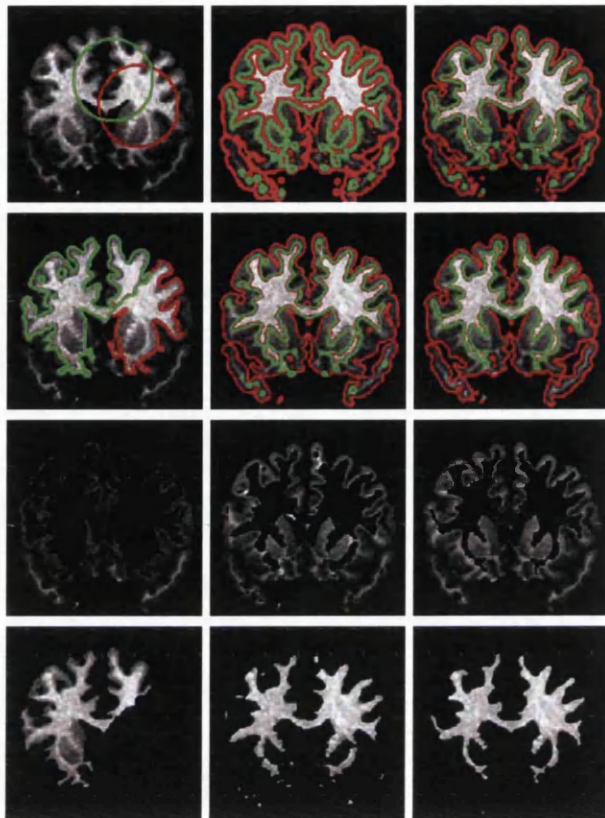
Example of MRI segmentation using active contour, showing the effect of three different initialization methods [13]. The top row shows the initial curves. The second row shows the stable curves obtained from the method; The last two rows show the segmented gray and white matter respectively. The first column shows manual initialization, which gives unsatisfactory convergence. The center column uses a threshold method based on coarse segmentation and right hand column uses pre-processing as suggested by [13].
